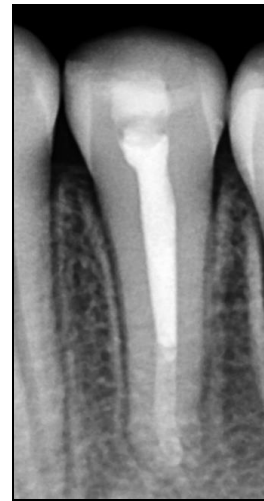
Radiographic control at 6 months
